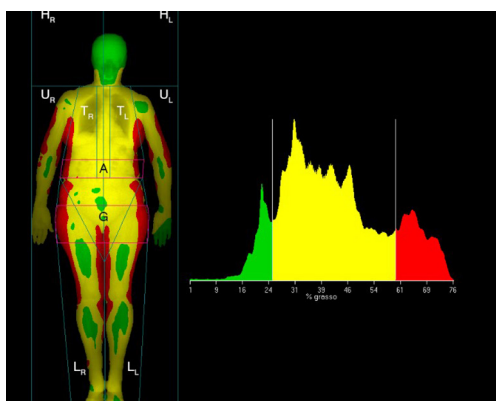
Whole body DXA scan. The image on the left shows the standard ROIs used for regional body composition analysis: head (H), trunk (T), upper limbs (U), lower limbs (L), android (A) and gynoid (G) regions. The colored soft tissues map and the histograms (on the right) show the distribution of fat in different body segments (red areas: fat percentage >60%; yellow areas: fat percentage 25–60%; green areas: fat percentage <25%). DXA, dual energy X-ray absorptiometry; ROIs, regions of interest.
